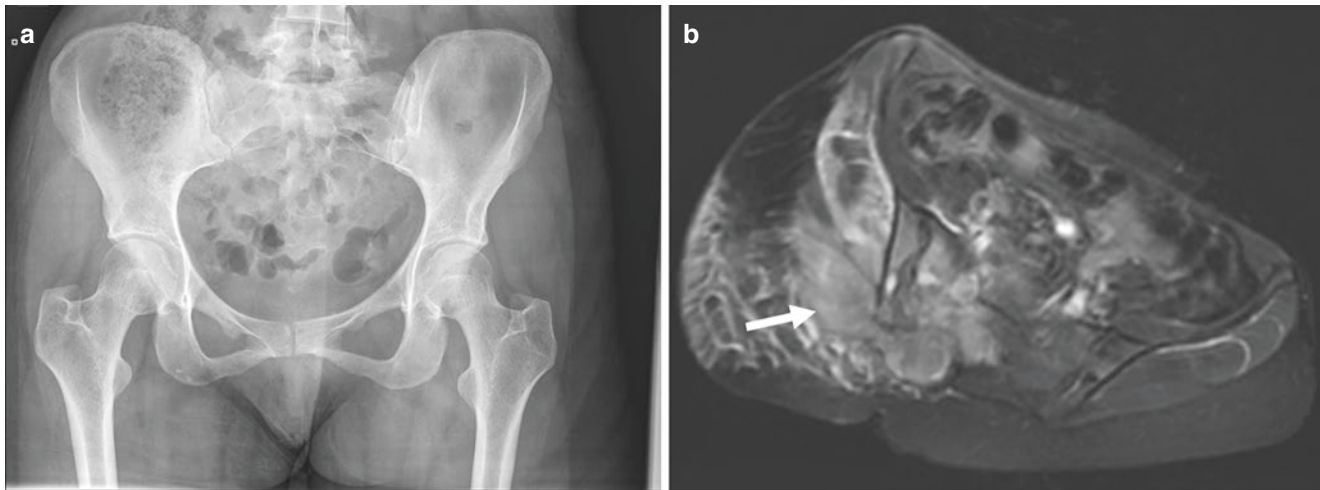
Frontal radiograph of the pelvis (a) highlights the limitations of plain radiographs in the diagnosis of pelvic tumors. A subsequent axial T2-weighted fat-saturated image of the pelvis (b) performed
